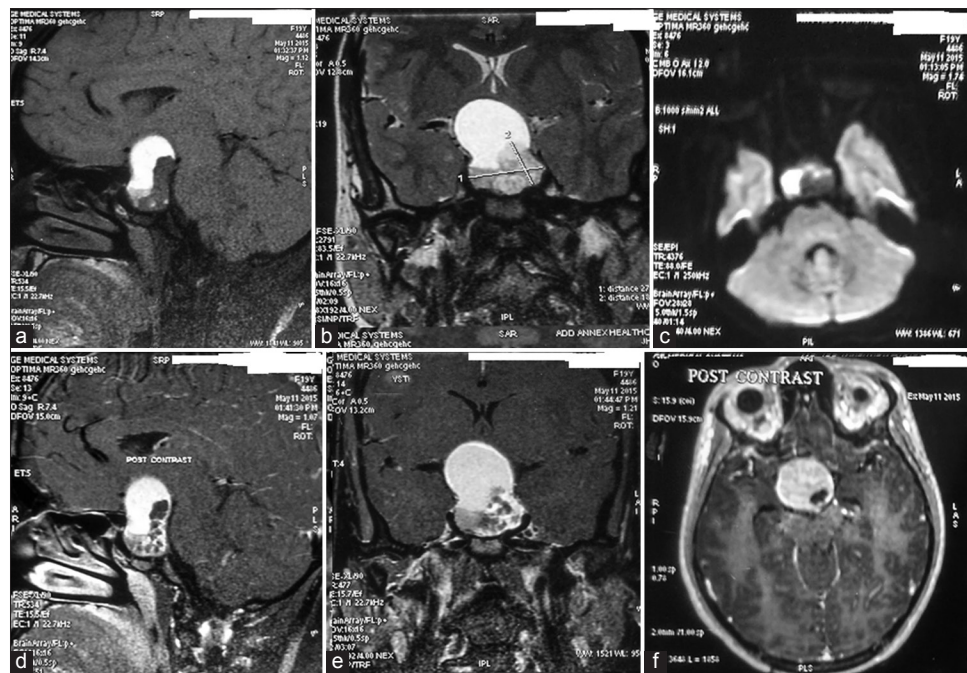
Magnetic resonance imaging pictures of the lesion. (a) T1-weighted sagittal image showing the lesion containing fat containing T1 hyperintense antero-superior and hypointense solid part in postero-inferior part. (b) T2-weighted coronal image of the lesion. (c) Diffusion image showing the solid part predominantly on left side. (d-f) Contrast images show the lesion to be minimally patchy enhancing
